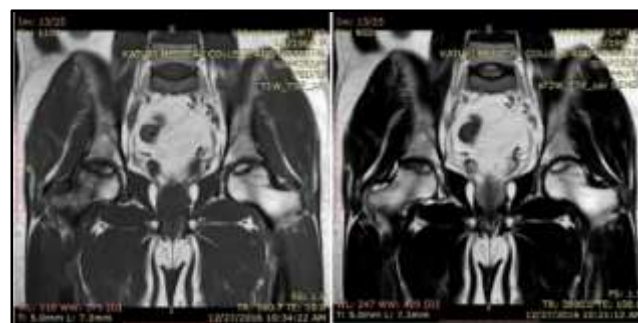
MRI T1W Coronal Sections showing Double Line Sign and Marrow Oedema of Right Femoral Head, Neck and Greater Trochanter in Patient with Avascular Necrosis of Hip
